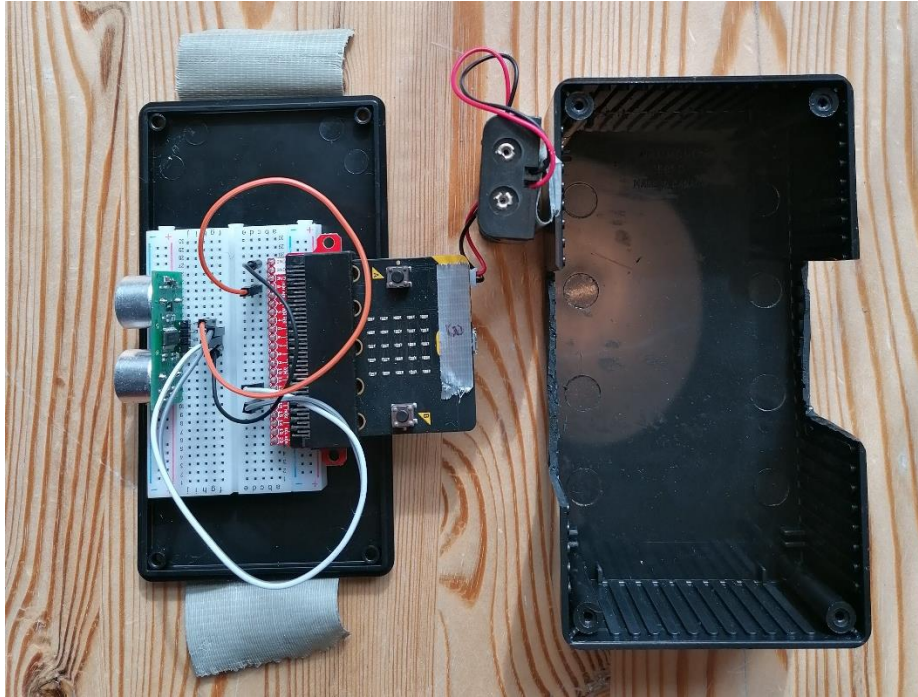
Ultrasonic sound sensor connected to the BBC micro:bit.
